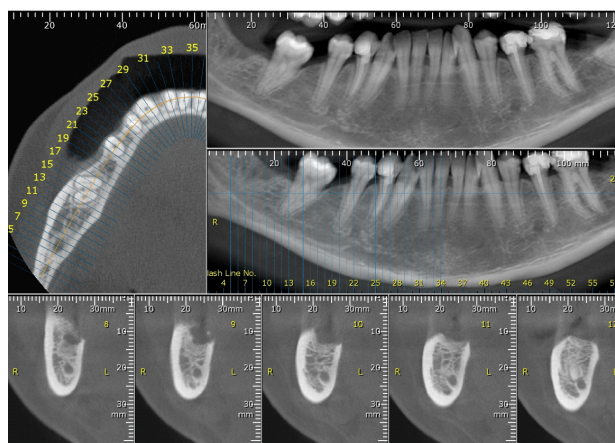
CBCT 3D images showing little ossification at a previous right mandibular extraction site. CBCT: Cone-beam computed tomography; 3D: Three-dimensional.
